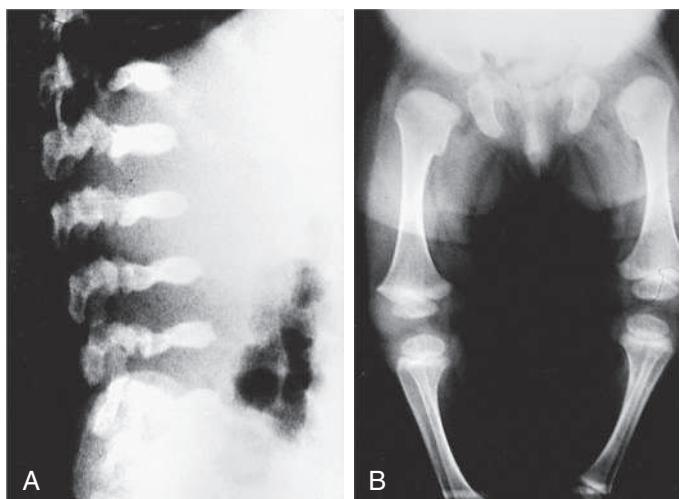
A, Radiograph of the lateral thoracolumbar spine in metatropic dysplasia showing severe platyspondyly. B, Radiograph of lower extremities in metatropic dysplasia showing short tubular bones with widened metaphyses. The femurs have a dumbbell appearance.
